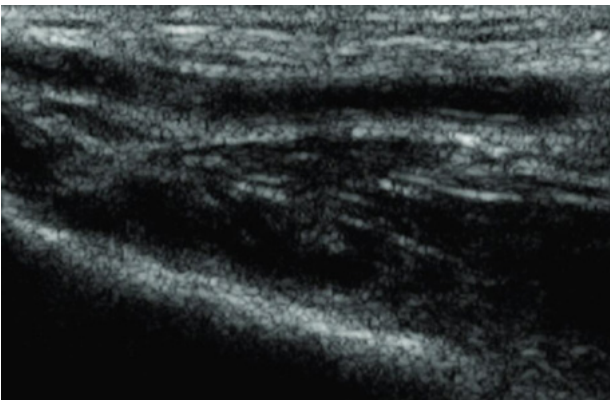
Longitudinal view on duplex ultrasound of a radial artery thrombosis after arterial line placement.
